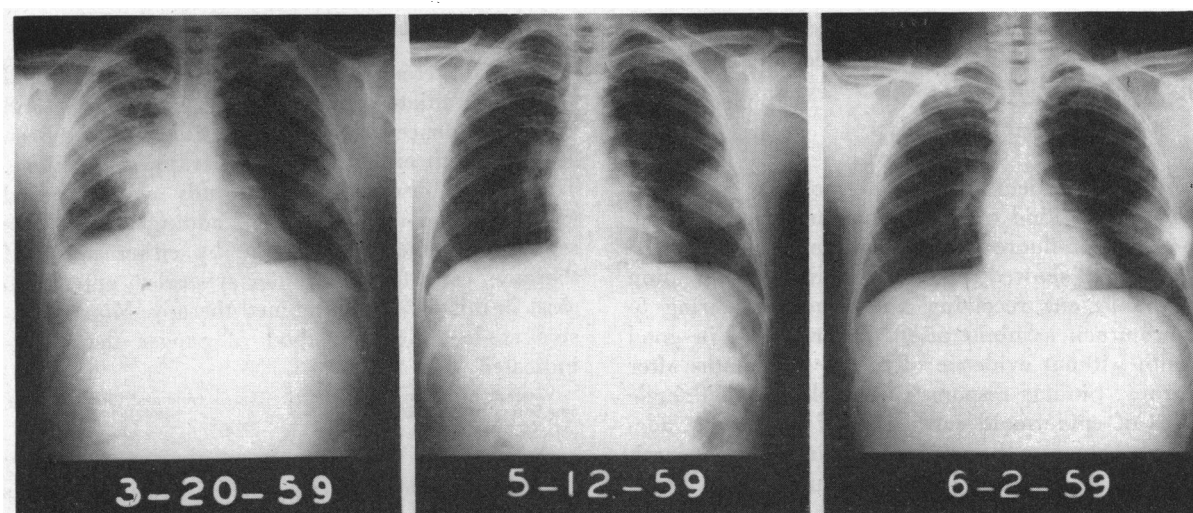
Embryonal cell carcinoma, with metastatic lesions in both lung fields. *Left*, before treatment. *Center*, two weeks after treatment with 5-fluoro-uracil. X-ray (2,000 r.) was administered concurrently to the lesion in the right lung. The mass in the left lung was exposed to 5-fluoro-uracil alone. *Right*, two weeks after treatment of left lung mass with x-ray (2,000 r.) alone.
